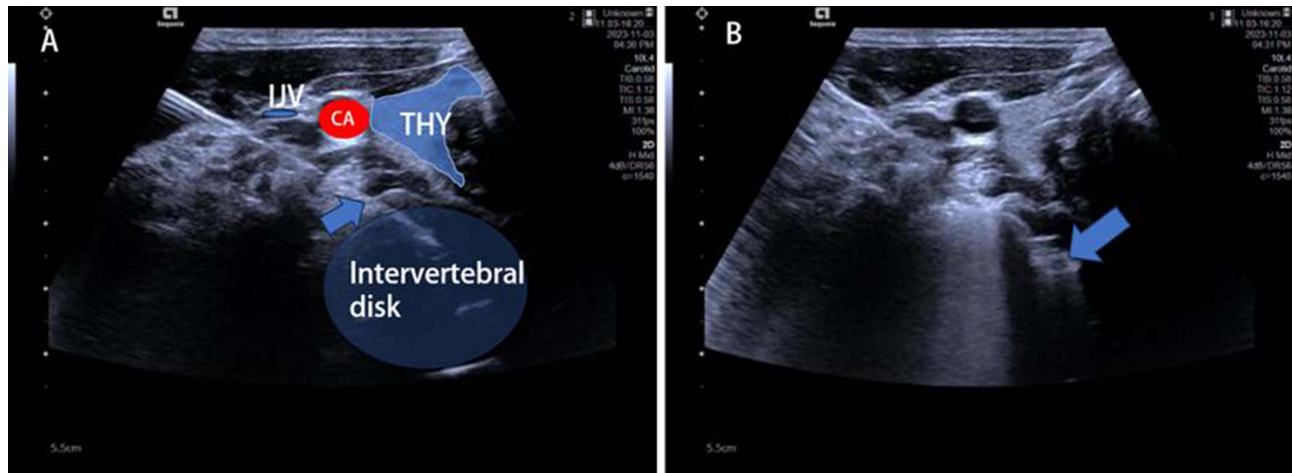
The process of the real-time ultrasound-guided CT-monitored percutaneous. (A) The needle is inserted into the C5-6 intervertebral disc (arrow indicates the needle tip, elliptical circle highlights the hypoechoic disc); (B) Ultrasound clearly demonstrates the drug injected into the C5-6 intervertebral disc (arrow indicates the hyperechoic drug).
